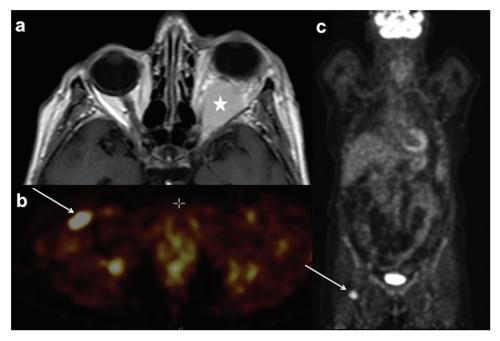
Usefulness of FDG-PET/CT in a patient with refractory inflammatory orbital disorder. A woman was admitted to hospital because of a corticosteroid resistant mass of the left orbit (a). Two years earlier, orbital biopsy had shown nonspecific inflammation. A mucosa-associated lymphoid tissue was finally evidenced owing to PET-FDG/CT-guided (SUV max: 5.1) right inguinal lymph node biopsy (b, c, arrows). A control biopsy of the mass was subsequently performed and confirmed the presence of the same low-grade lymphoma in the orbital tissue (a, star).
